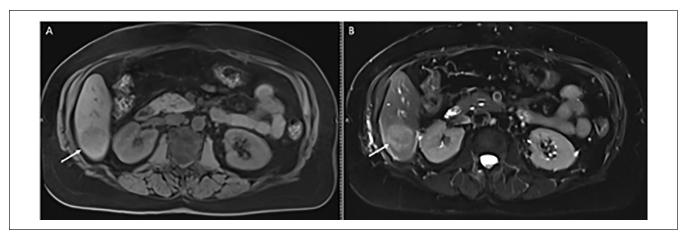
Axial unenhanced (A) T1-weighted and (B) T2-weighted images of the abdomen with fat saturation demonstrate a round lesion within hepatic segment 6; the lesion is hypointense on T1-weighted and hyperintense on T2-weighted images (white arrows).
